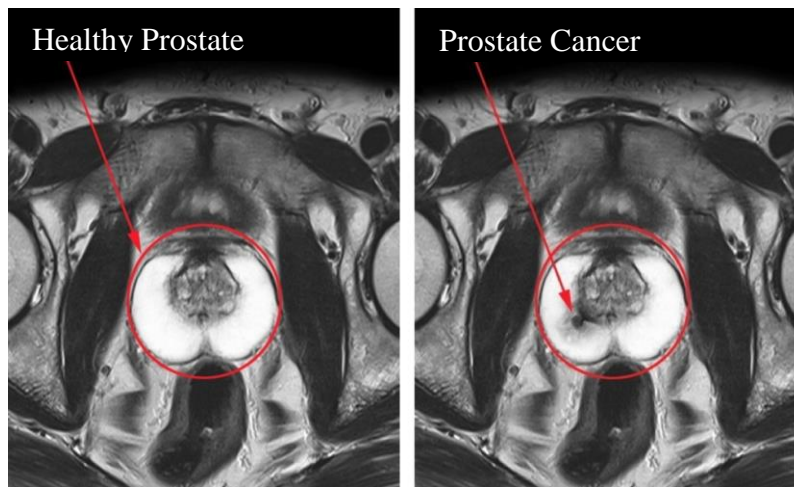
MRI scans of healthy prostate (left) and prostate cancer (right). MRI scans provide higher contrast than CT scans, making it easier to identify anatomical borders for contouring [16].
